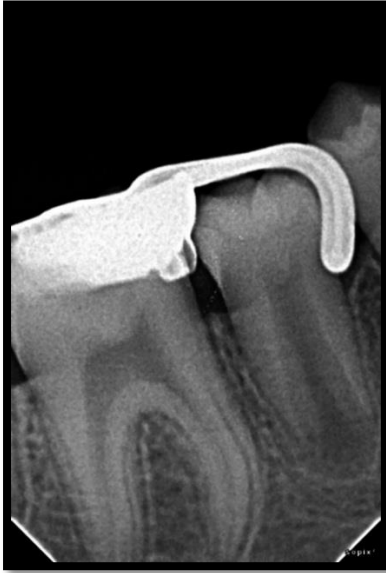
Radiograph revealing the eruption of second premolar
